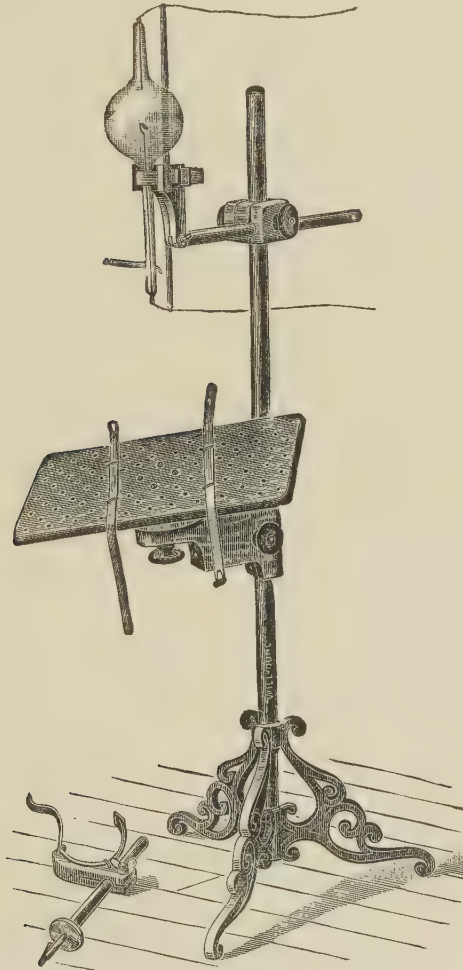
X-ray Stand with Tube and Plate Holder.
